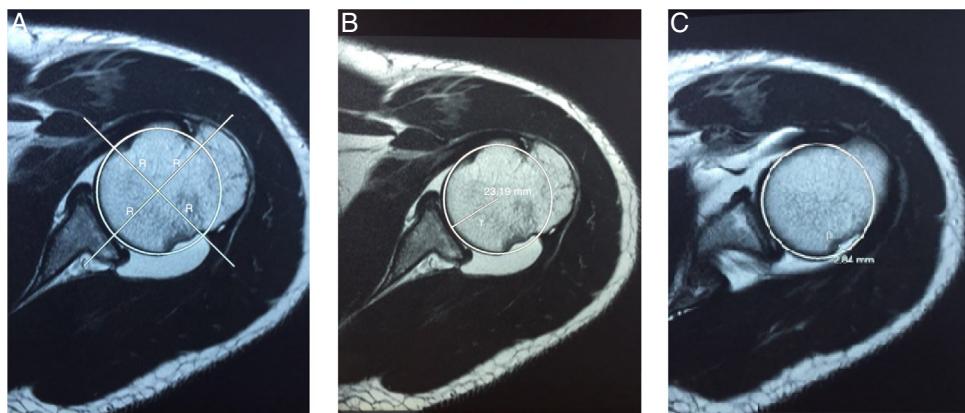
Demonstration of Hardy index assessment on MRI/MRA. (A) The line that circumscribes the humeral head determines the best fit. The two perpendicular lines must have radii (R) with the closest possible values between them, thus determining the center of the head; (B) humeral head radius (r); (C) depth of the HSL defect (p). The Hardy index is calculated as the ratio of the depth (p) over the radius (r): p/r. It is important to note that (p) and (r) are measured at different levels of the humeral head (the HSL is posterosuperior and the largest radius (r) is more inferior to it).
